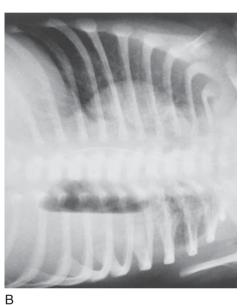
Lung abscess in a 2-week-old boy with a cavitary lesion in the left side of the chest. A, Supine anteroposterior chest radiograph demonstrates a large cavity in the left lower lobe, causing a mediastinal shift to the right. B, Left side-down decubitus film shows a large air-filled level within the cavity.
